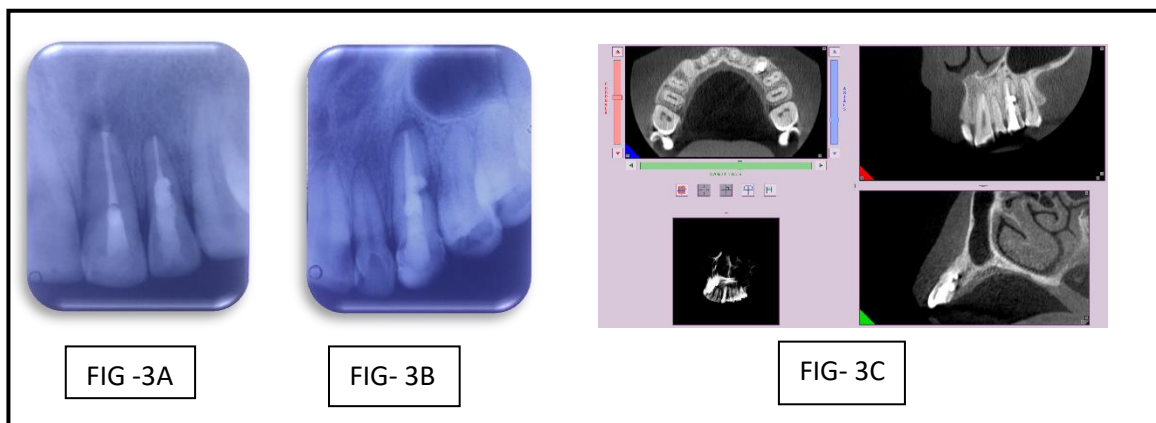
Follow up IOPAR of 1st case, 3B-Follow up IOPAR of 2nd case ,3C- Follow up CBCT of 2nd case
